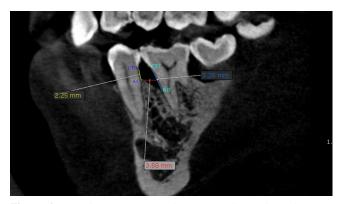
cone beam computed tomography at baseline – sagittal view - Vertical depth of defect-Alveolar crest height- Width of defect
